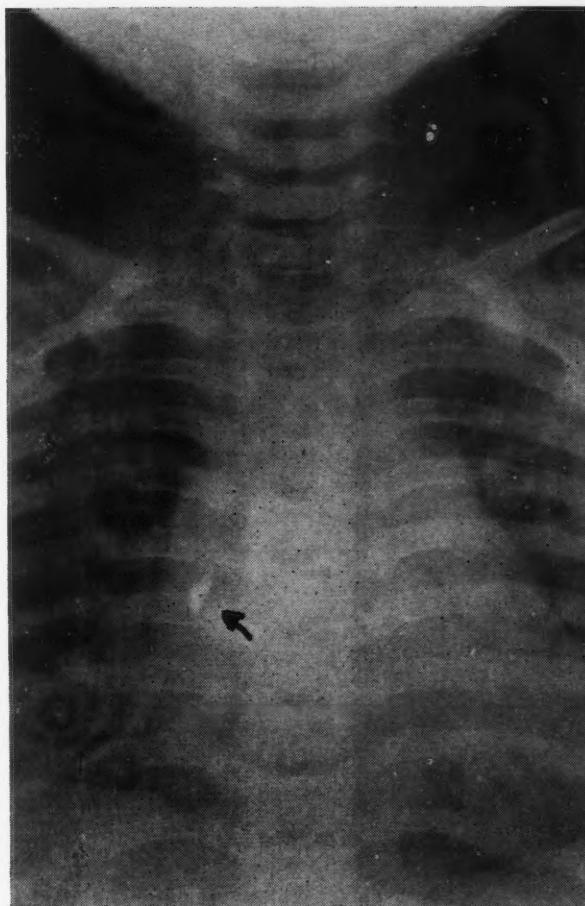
Stone in right bronchus. A., age 16 months. September 2, 1953. While playing, child aspirated a foreign body. She choked and for several minutes had difficulty in catching her breath. Then she began to wheeze and had paroxysms of coughing. She was admitted to a hospital, where an x-ray of the chest showed a radiopaque foreign body triangular in shape, in the right main bronchus. There was obstructive emphysema of the right lung. Bronoscopies were carried out and a tracheotomy was done. Owing to the difficulty experienced in removing the foreign body I was called in consultation. Under light ether anaesthesia I passed an infant-size bronchoscope through the tracheostomy opening. The mucous membrane of the right bronchus was so swollen that it covered the foreign body. After aspirating the pus and controlling the bleeding from the granulations, the foreign body was removed trailing the bronchoscope. It proved to be a little stone, coal black in appearance. The breathing immediately improved. Patient was discharged cured.
